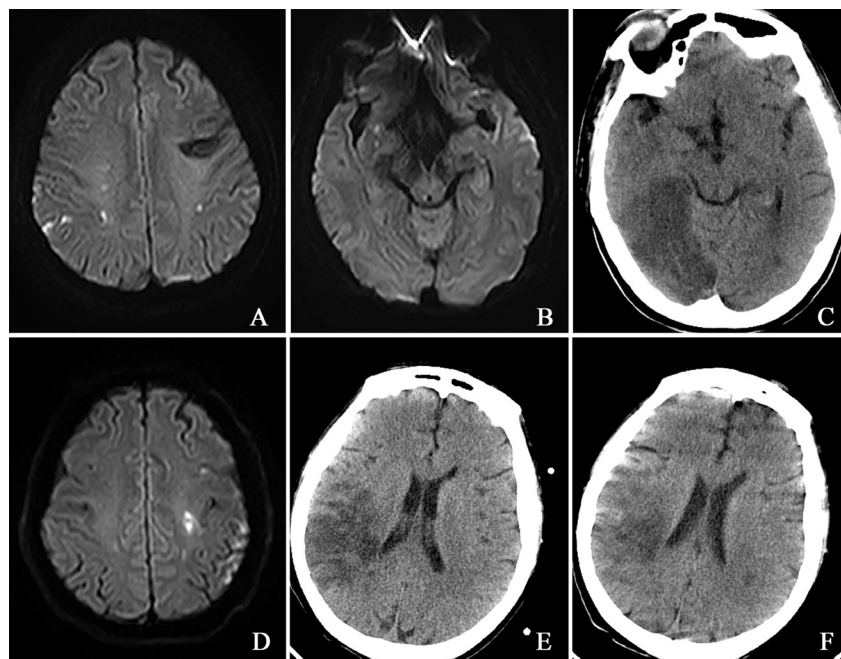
Image data of patient. A and D display cerebral infarcts at different stages (acute and subacute). Images B and C are from Diffusion Weighted Imaging (DWI) and cranial CT scans taken on the second and fifth days of hospitalization, respectively, showing new infarct lesions in the right temporal lobe. Images E and F are from cranial CT scans on the third and eighth days after admission, depicting new acute cerebral infarct lesions in the left centrum semiovale of the parietal lobe.
